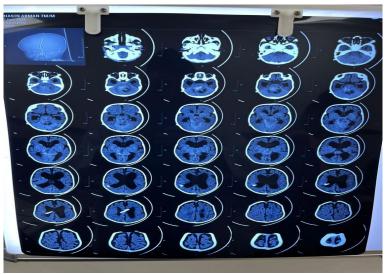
Complication- Shunt Obstruction (CT Image)
